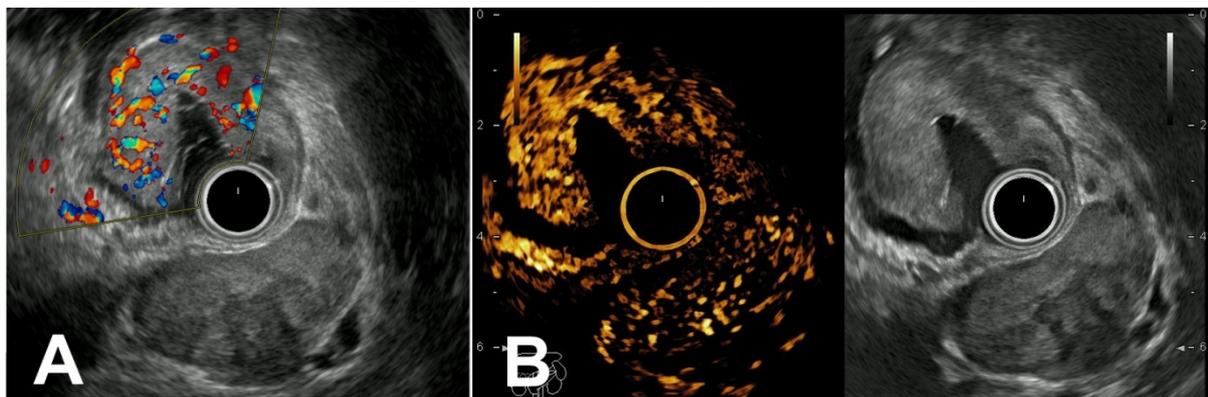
(A) Doppler examination during EUS revealed increased intratumoural vascular signal; (B) Contrast enhanced EUS image showing homogenous tumour enhancement during the arterial phase (contrast image on the left and conventional B mode examination on the right).
